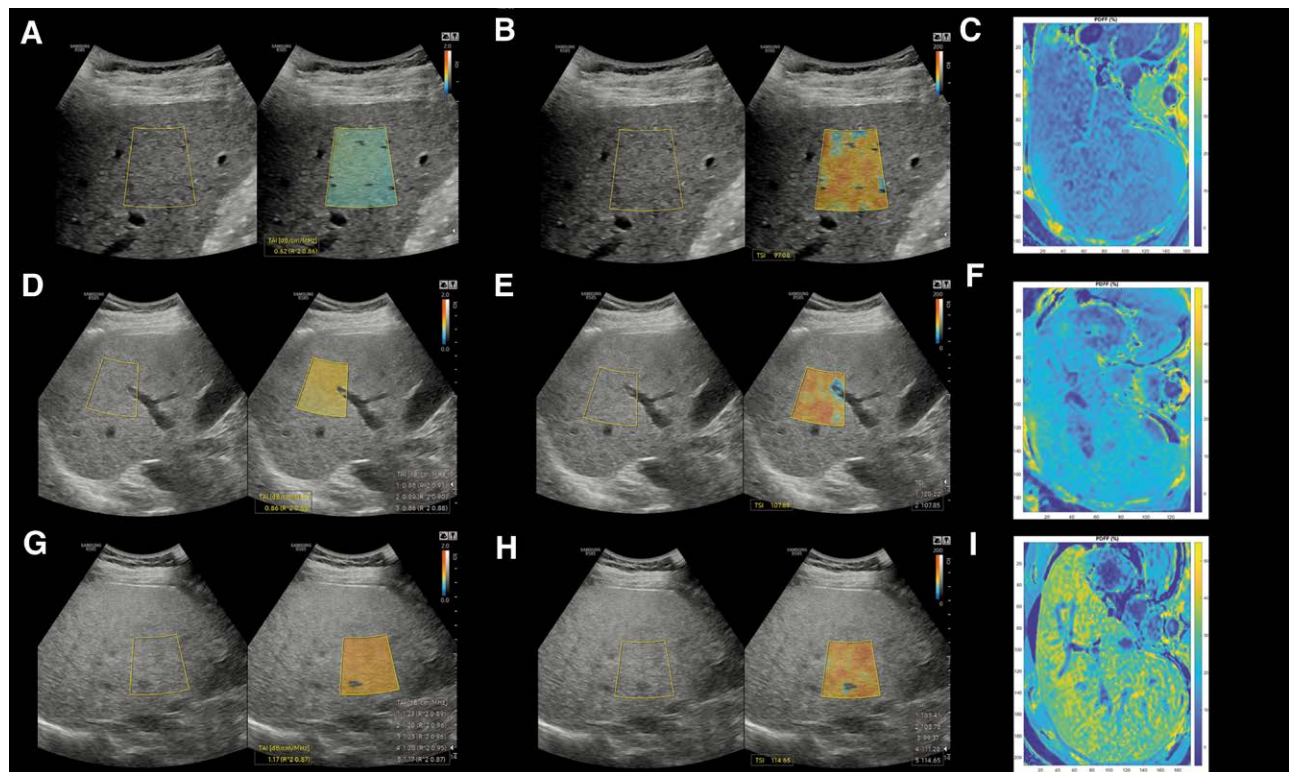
Quantitative ultrasound measurement of the liver fat. Tissue attenuation imaging (A) and tissue scatter distribution imaging (B) of participants with a liver fat content of <5%. For visual reference, colormaps from magnitude-based estimation of MRI-PDFF values were also reconstructed on axial slices where livers with < 5% MRI-PDFF showed blue color indicating no significant steatosis (C). Patients with 5–10% of MRI-PDFF had higher TAI (D) and TSI (E) values compared to patients with no significant hepatic steatosis, while the MRI-PDFF colormaps of the liver turned green (F). Finally, patients with ≥ 10% of MRI-PDFF had the highest TAI (G) and TSI values (G), and they had a yellowish color on the MRI-PDFF colormaps (I). MRI-PDFF = magnetic resonance imaging-based proton density fat fraction measurement, TAI = tissue attenuation imaging, TSI = tissue scatter distribution imaging.
